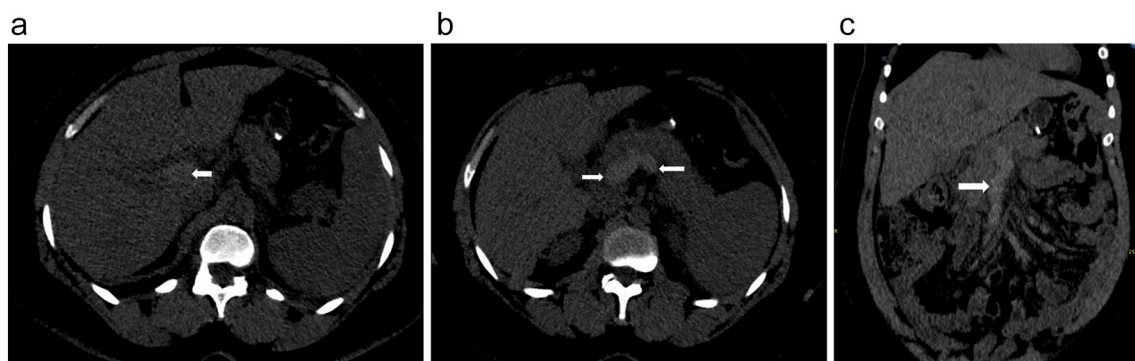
a. Un-enhanced CT scan abdomen axial view demonstrating intrahepatic portal vein enlarged with spontaneous hyperdense material in keeping with acute thrombosis (arrow).
